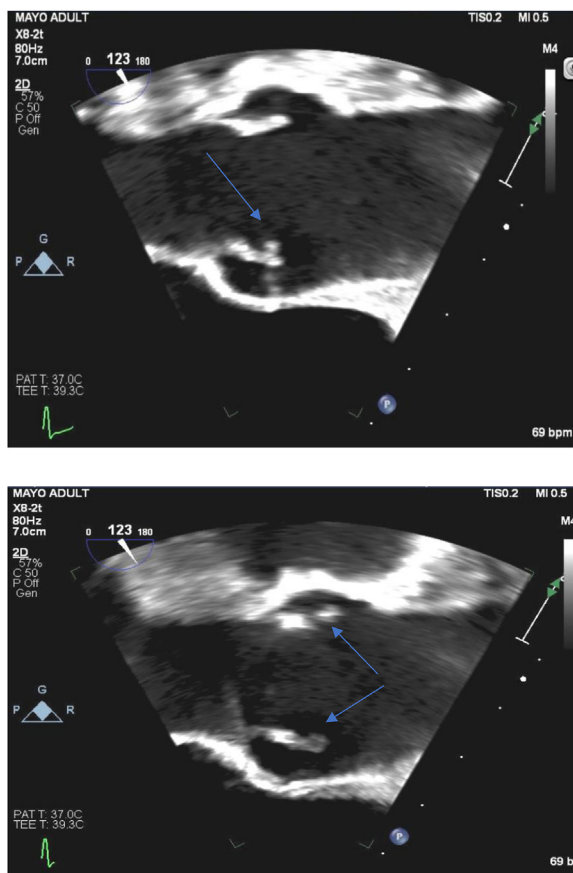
Mid esophageal Transesophageal Echogram (TEE) of Left ventricular outflow tract and Aortic valve and ascending aorta. The vegetation appears to be associated with both the non-coronary and right coronary cusps. There is no significant insufficiency.
